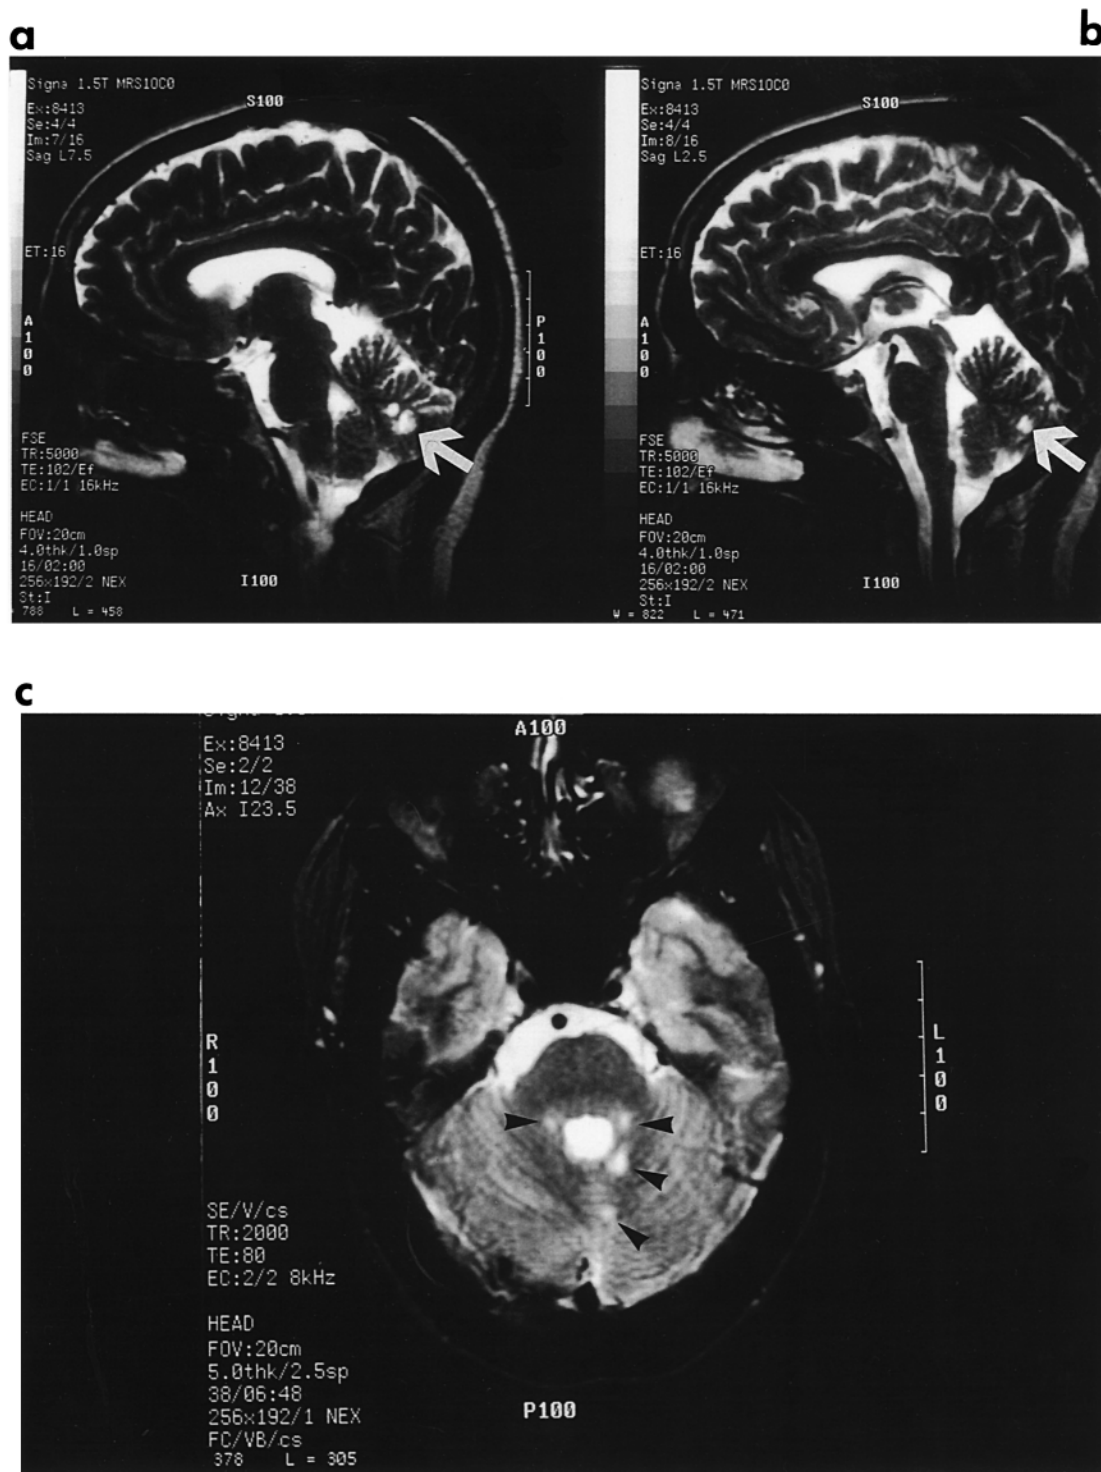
Magnetic resonance imaging scan of AL (1993). (a) and (b) show T2-weighted (proton density) sagittal images demonstrating small areas of increased signal in the left cerebellar vermis (white arrows). (c) shows the horizontal view (proton density) with no clear abnormality in the temporal cortices, but the deep cerebellar lesion is again visible (black arrows).
